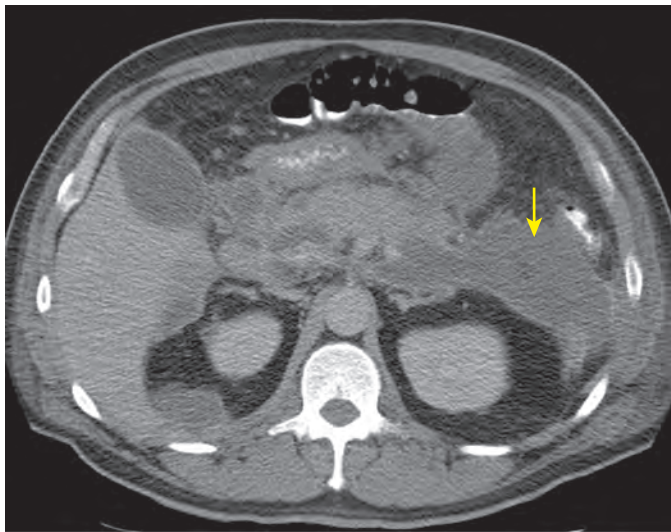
Pancreatitis: CT features. An inflammatory fluid collection (arrow) is identified in the left anterior interfascial plane on this axial image.
